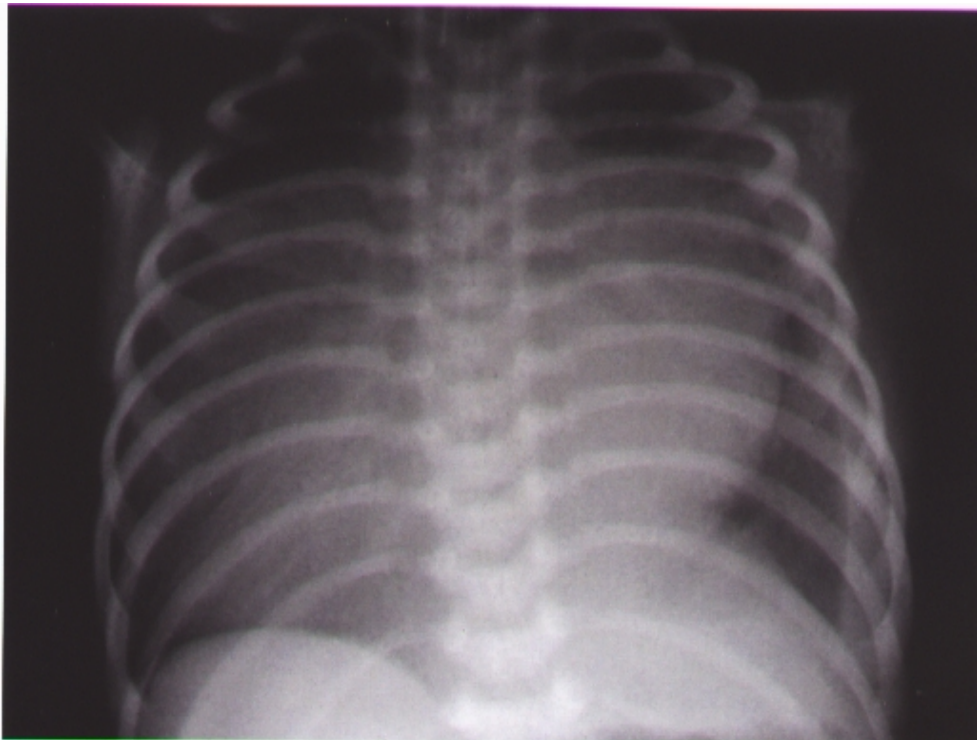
Chest roentgenogram on the second day of life revealing an enlarged cardiac silhouette with left pleural effusion.
